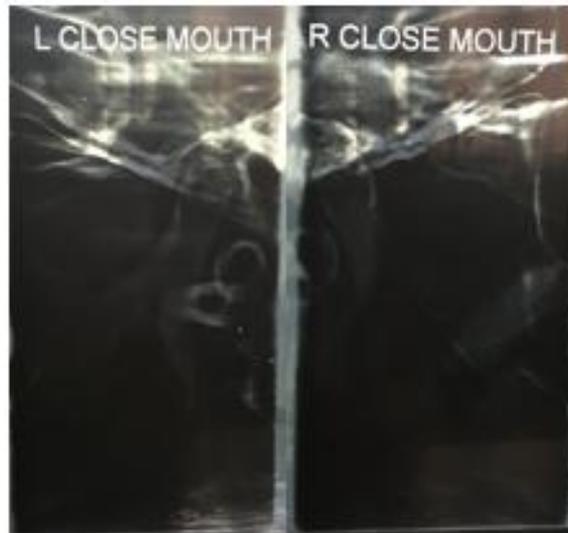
TMJ Radiographic Examination (Close Mouth)
